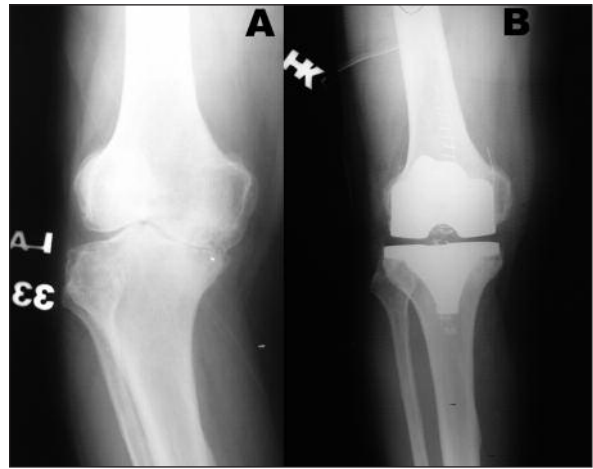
A-The initial x-ray of the patient before primary arthroplasty, B- Early postoperative x-ray of the patient.
